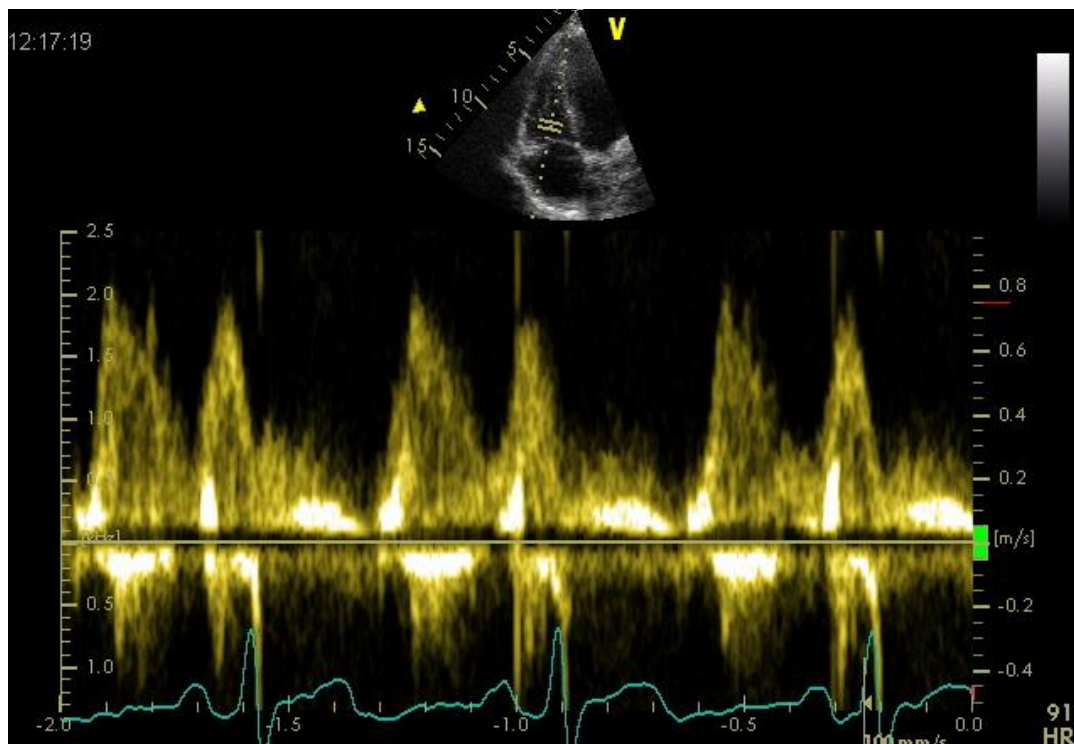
Pulsed wave Doppler of the TV, measuring forward flow across the valve
